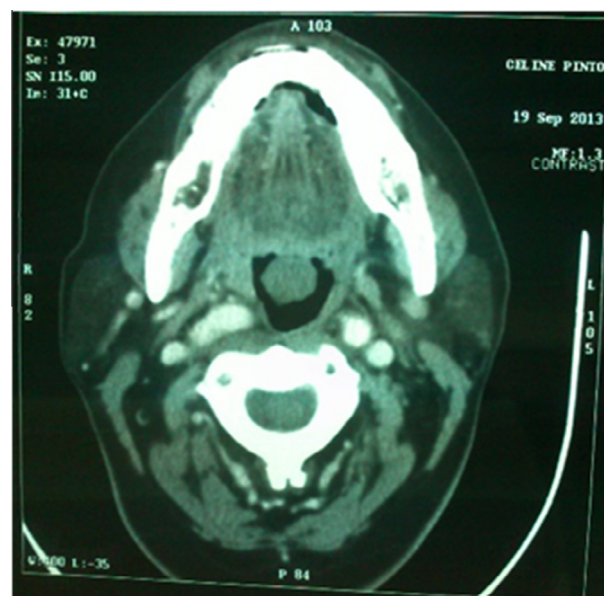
CT scan image showing mildly enhancing lesion attached to tongue base.
